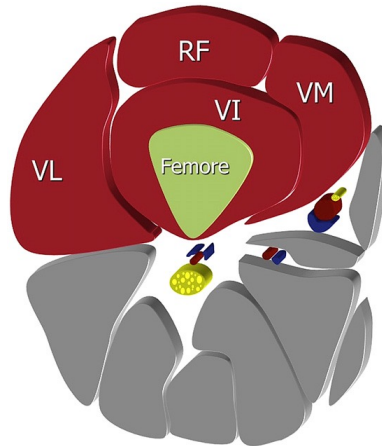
Anatomy of the quadriceps muscle (axial plane). VL = vastus lateralis; VI = vastus intermedius; VM = vastus medialis; RF = rectus femoris. Modified after “Sonography of the quadriceps muscle: Examination technique, normal anatomy, and traumatic lesions” (Pasta, Nanni et al. 2010).
